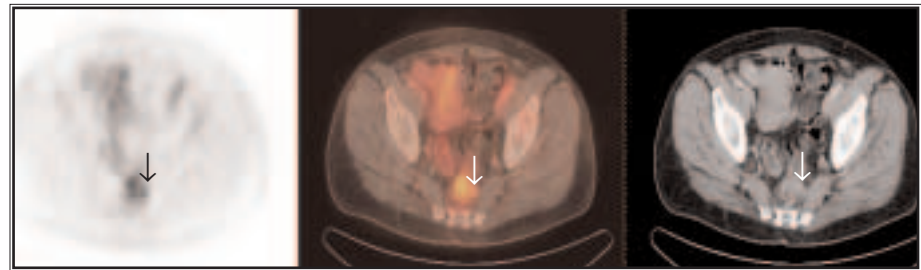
Lymph node left of rectum with increased FDG uptake (arrow). Axial images. Left: PET. Middle: Fused PET/CT. Right: CT image.
